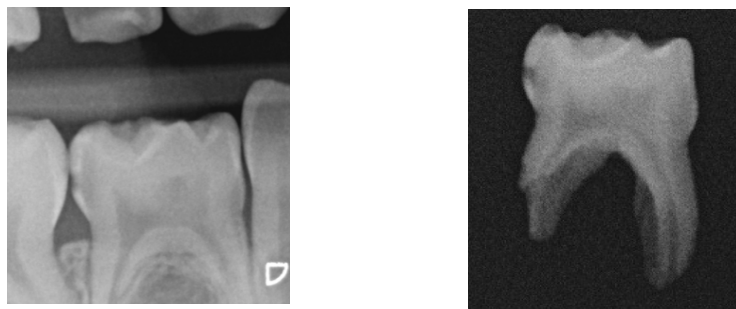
In-vivo (Left) & in-vitro (Right) radiograph showing early dental caries
